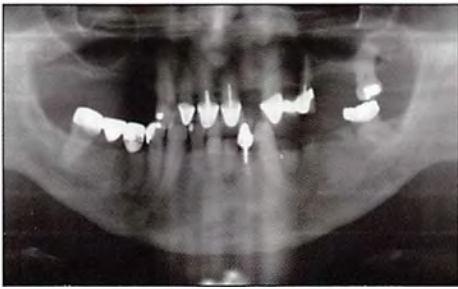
Panoramic radiograph showing teeth with a questionable long-term prognosis.
